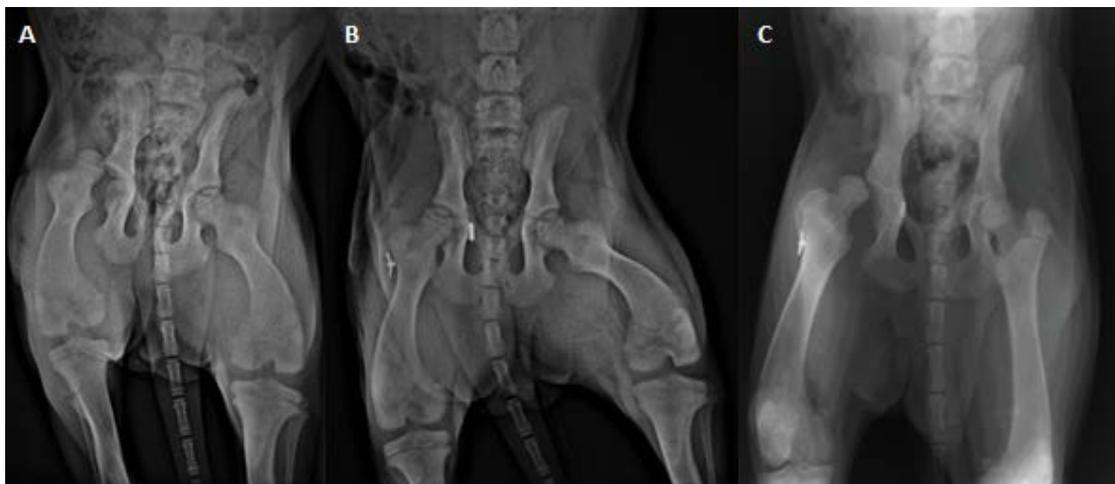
Ventrodorsal radiographic images of case 4, A) preoperative, B) immediately after surgery, C) 5th day after surgery.
